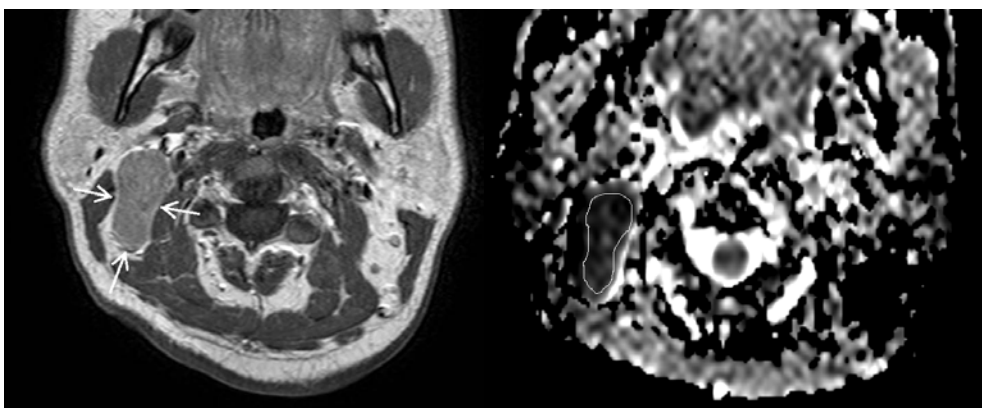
Post-contrast T1-weighted image (left) shows the malignant node (arrow) and ADC map (right) shows the region of interest drawn around the malignant node.
